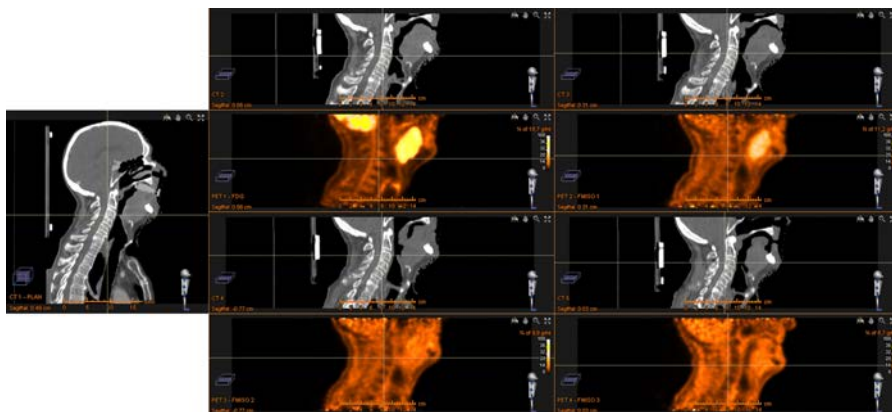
Sample of available images (Patient 22): planning CT on the left; CT-FDG PET pair on the high left corner; CT-FMISO PET 1 on the high right corner; CT-FMISO PET 2 on the low left corner; CT-FMISO PET 3 on the low right corner.
